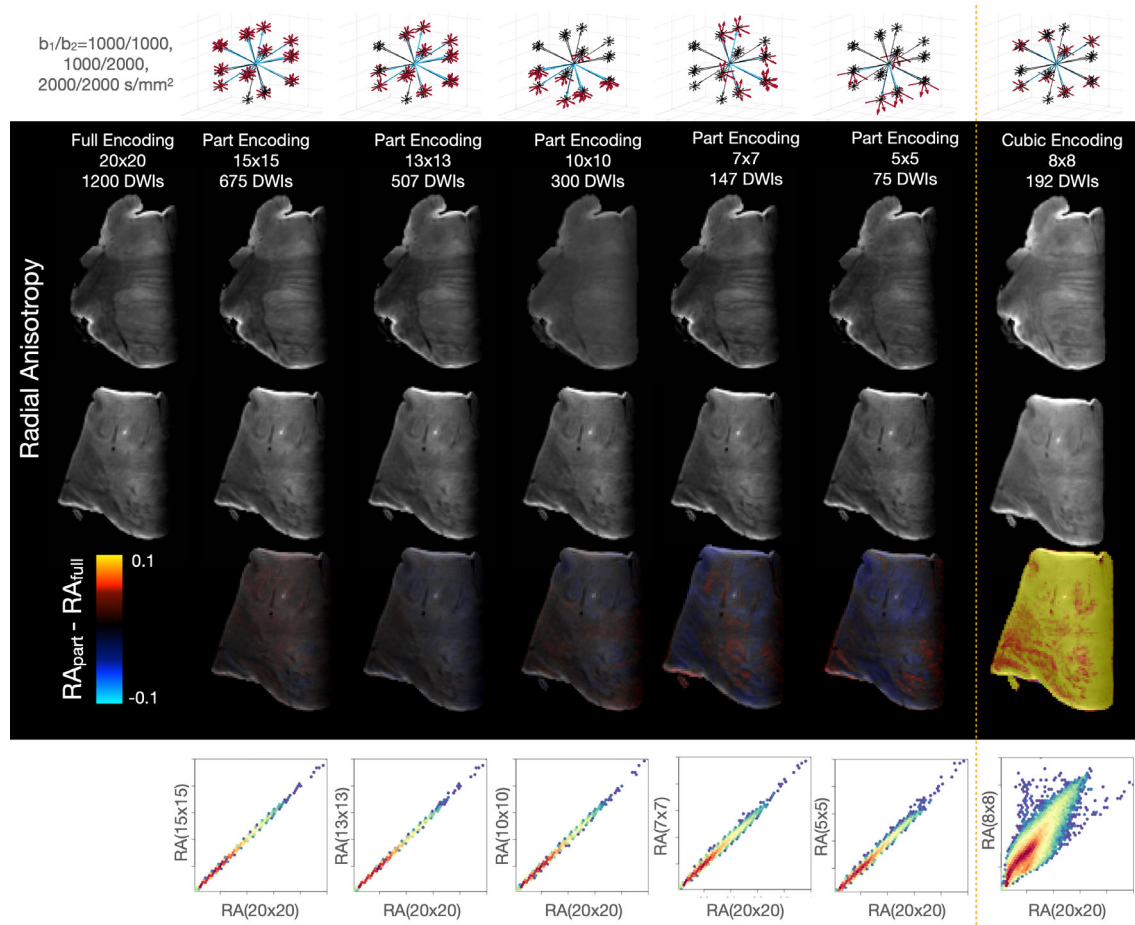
The influence of angular encoding on radial anisotropy (RA) was evaluated using subsampled data sets according to the vector plots and labels at top as described in the text. Little qualitative changes were observed in contrast across all subsampled sets, even the lowest (5×5), although difference map and two-dimensional histogram changes were evident for one 10×10 subspace and for the 7×7 subspace. Undersampling to cubic encoding (right column) resulted in prominent increases in RA values, although similar tissue contrast was maintained. DWI, diffusion-weighted image.
